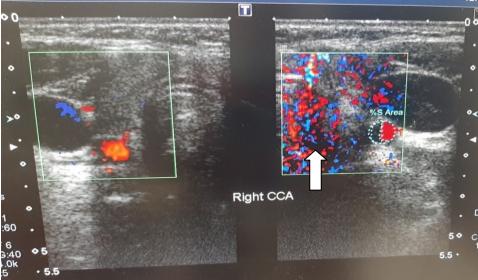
Doppler of Right and Left common Carotid Arteries in controls.
